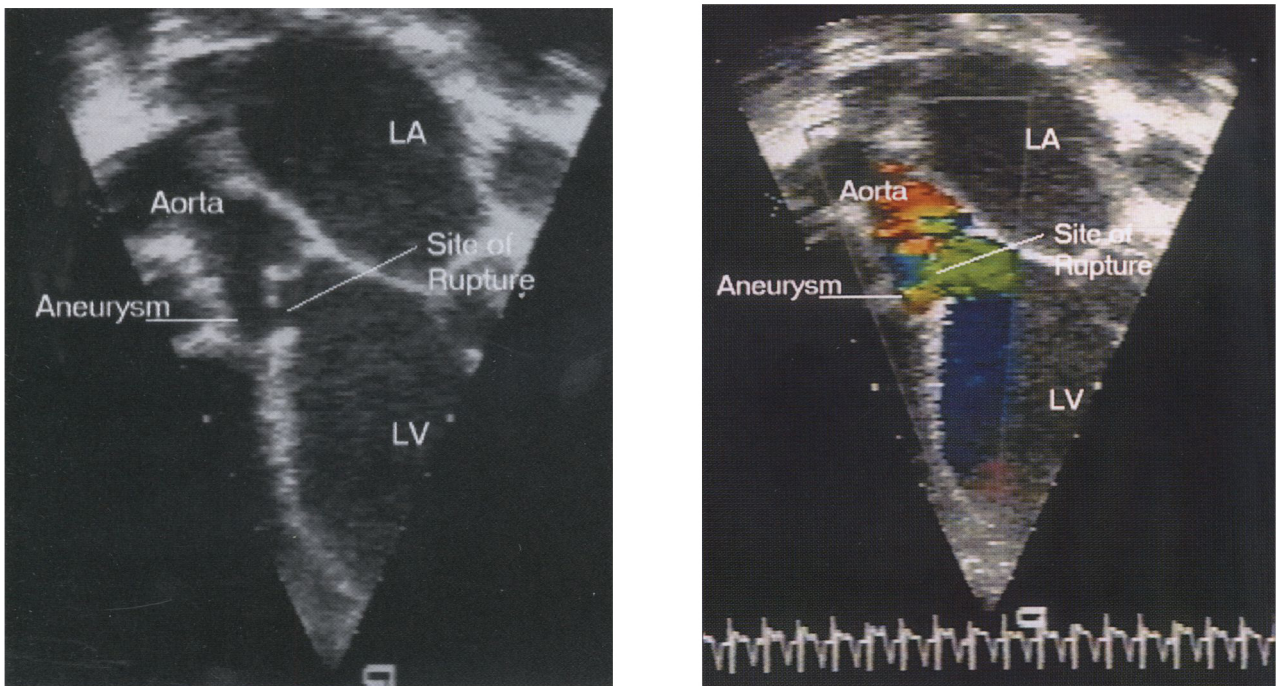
a). Apical four-chamber view; b). apical four-chamber view (colour Doppler). LA: left atrium; LV: left ventricle.
